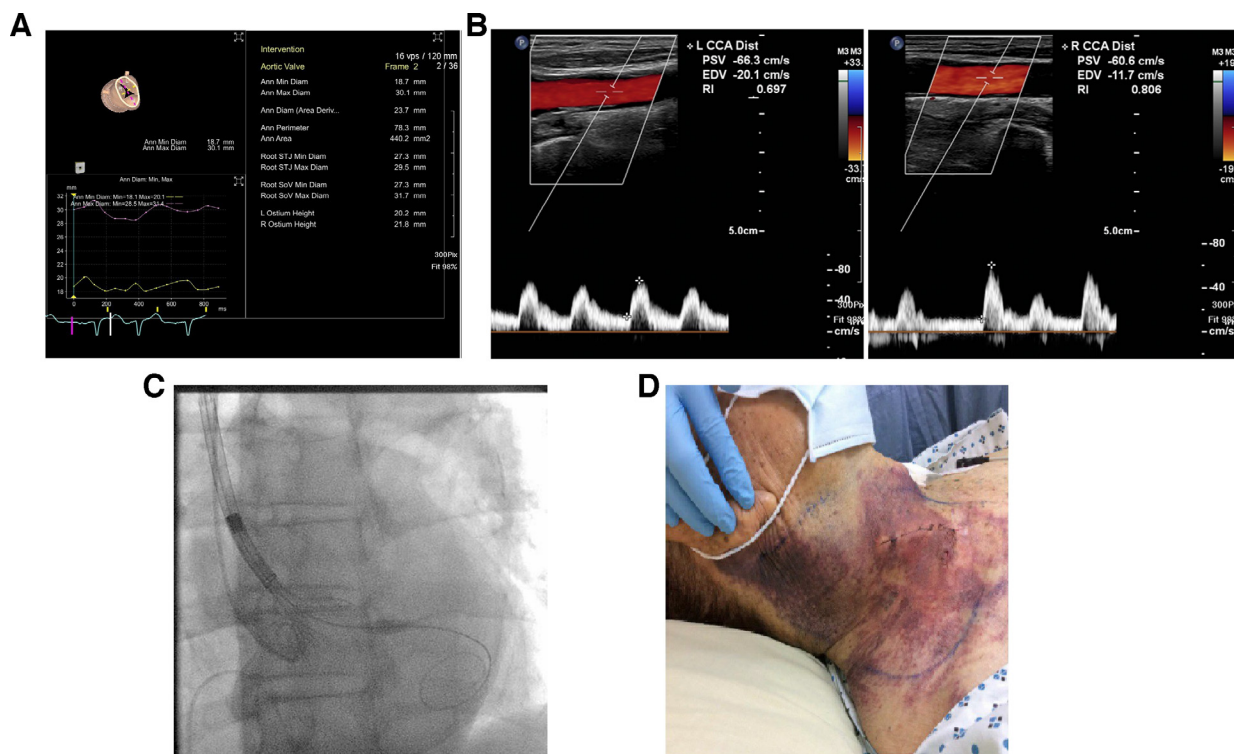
(A) Three-dimensional transesophageal echocardiogram using analysis software (ACUSON SC 2000 PRIME, Siemens Medical, Erlangen, Germany) revealing an estimated aortic annulus perimeter of 78 mm. (B) Carotid artery sonogram reveals patent bilateral carotid arteries with an estimated right common carotid artery diameter (Diam) of 8.9 mm. (C) Deployment of CoreValve Evolut R 29 mm (Medtronic, Minneapolis, MN) to the aortic annulus via the right carotid artery approach. (D) Right neck wound 2 days after surgery. Ann, annulus; CCA, common carotid artery; Dist, distal; EDV, end-diastolic velocity; max, maximum; min, minimum; PSV, peak systolic velocity; RI, Doppler resistive index; STJ, sinus tubular junction.
